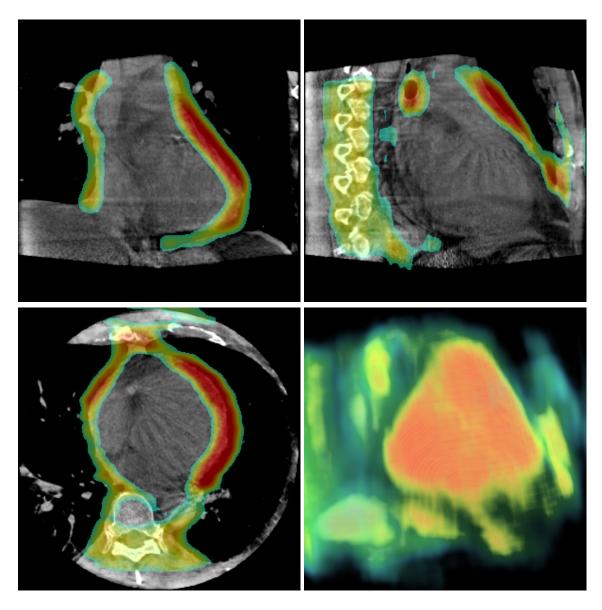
Slices of the original C-arm CT volume (*F*) overlaid by the PBT-based probability map (thresholded), red color indicates high probability, blue colored and transparent regions are rather unlikely to contain the pericardium boundary. Lower right: Tilted frontal 3D rendering of the probability map.
